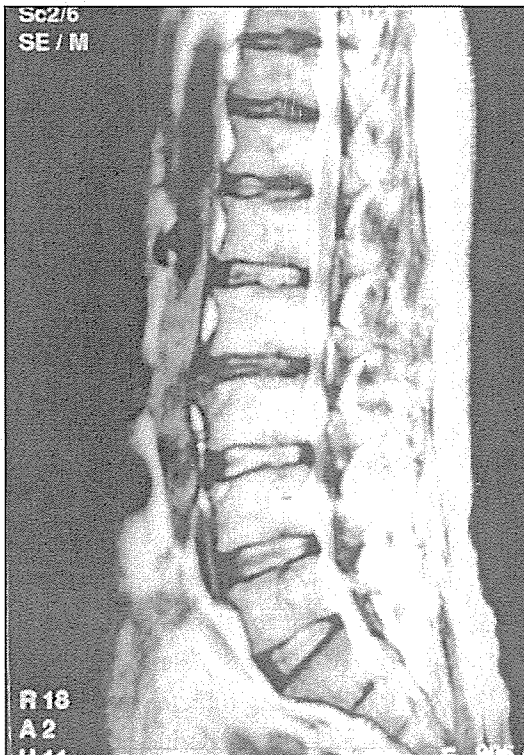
MRI of a patient with degenerative lumbar spinal stenosis.
